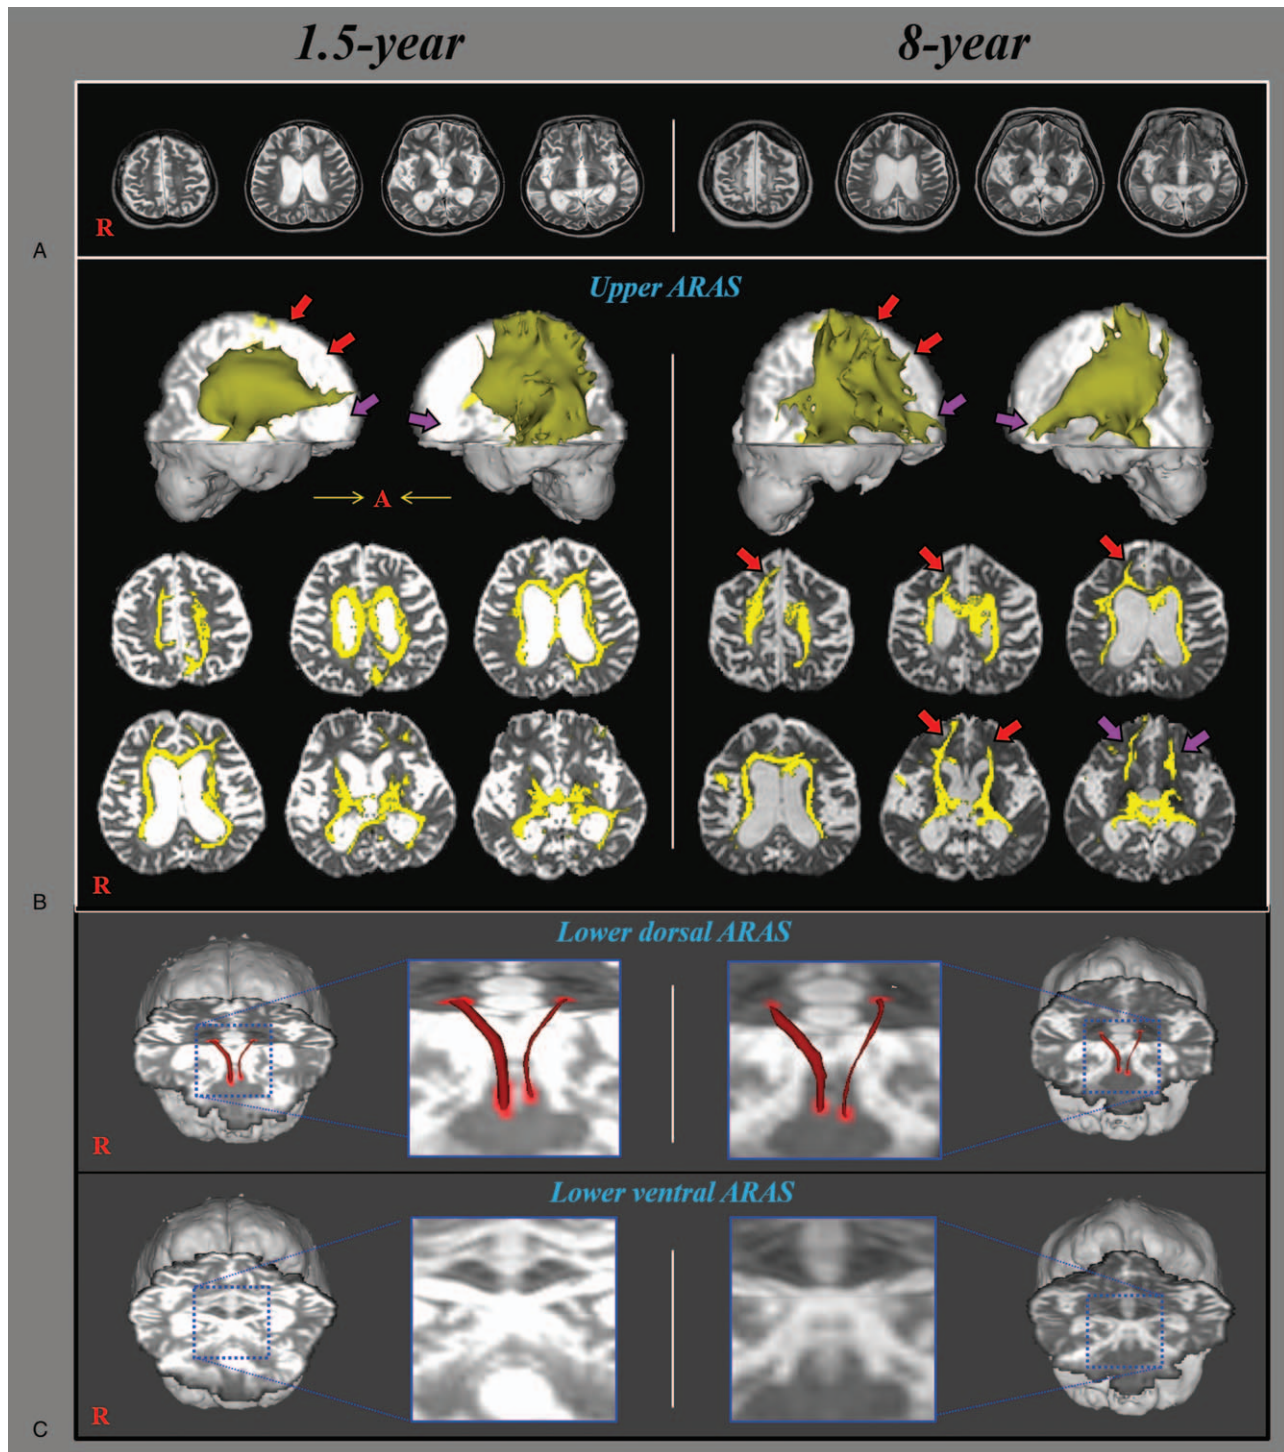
(A) T2-weighted MR images at 1.5 and 8 years after onset show no abnormality. (B) Results of diffusion tensor tractography (DTT). In the upper ascending reticular activating system (ARAS), the neural connectivity to both the basal forebrain (purple arrows) and prefrontal cortex (red arrows) is increased on 8-year DTT compared with 1.5-year DTT. In the lower dorsal and ventral ARAS, no significant change is observed between 1.5- and 8-year DTTs (thinner left lower dorsal ARAS and non-reconstructed both lower ventral ARAS).
